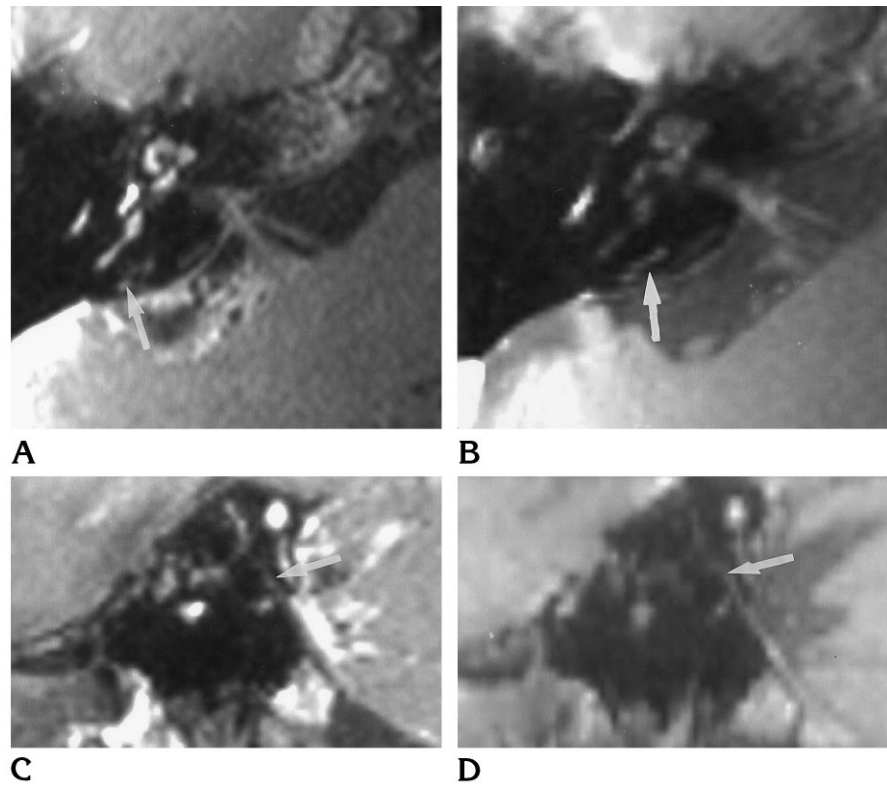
Steady state (A and C) and T1-weighted (B and D) MR images of the symptomatic ear of a 65-year old woman with a 4-year history of Meniere disease (subject 6 in Table 2).
